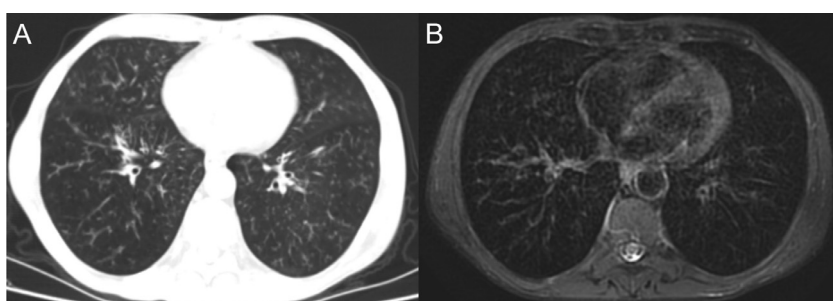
A 61-year-old male patient with a centrilobular nodular pattern, which is one of the rare findings in COVID-19-related pneumonia. Although the nodules are easier to distinguish on CT, this pattern is also shown very successfully on the MRI image.
